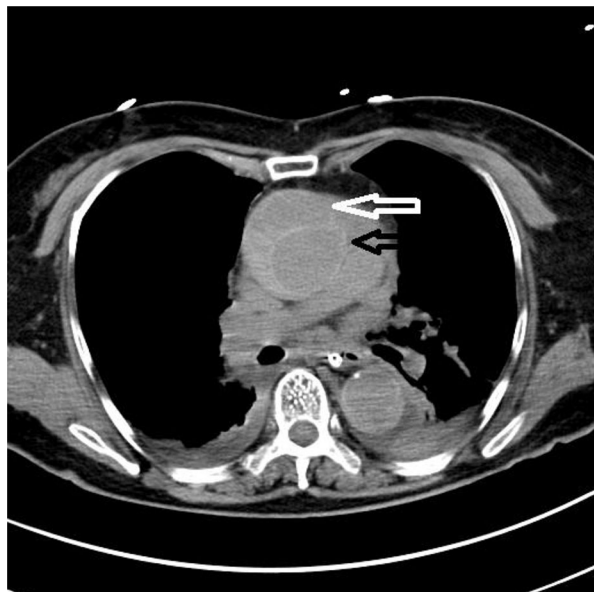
Non-contrast chest CT showing false and true lumens of the ascending aorta (white and black arrows, respectively).
